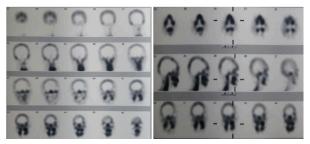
Bone SPECT coronal, axial and sagital images for a case of active left condylar hyperplasia.
